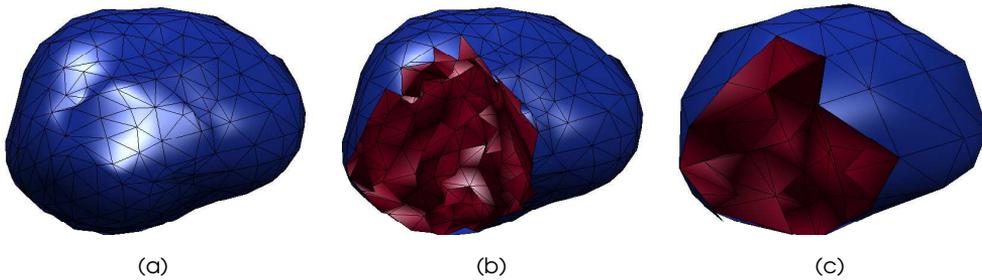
An example showing a tetrahedral volume mesh of the prostate contour obtained from the masked MR image: (a) shows the outer prostate surface; (b) shows some of the inner elements by taking out a quarter of the mesh; and (c) shows a coarser mesh of the same prostate containing less elements of a larger volume.
